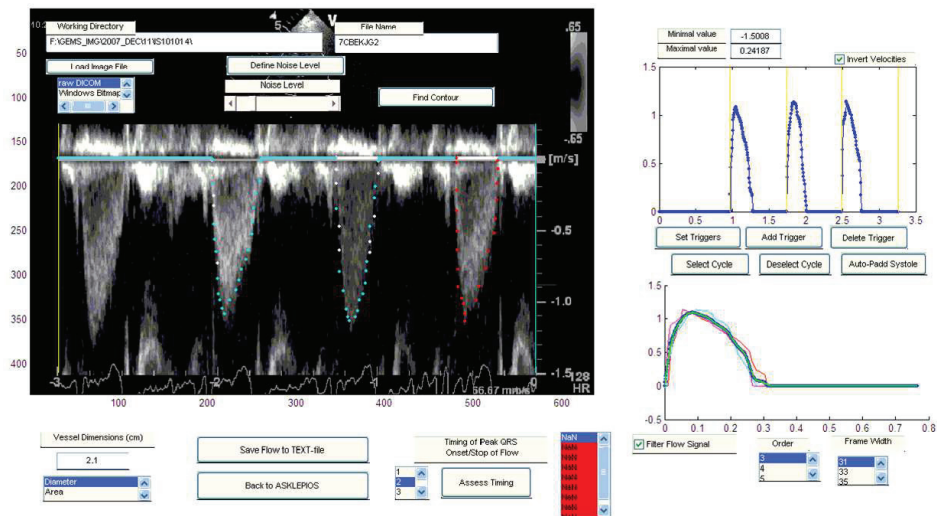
From the Matlab program, Doppler recordings. The raw data recordings are shown in the left panel. The operator draws points on the flow image to derive the aortic flow over three cycles. Selected cycles from Doppler registrations in LVOT that is used to calculate the average waveform is shown in the upper right panel. The average flow signal from 3 selected waveforms is shown in the lower right panel.
